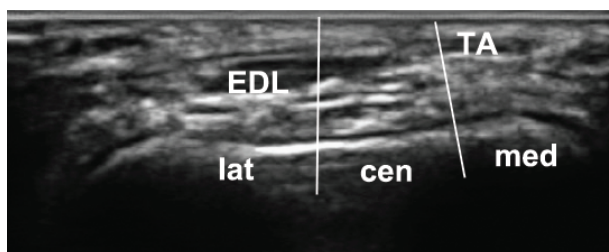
3. three zones used to identify the location of the defects on ultrasound.
